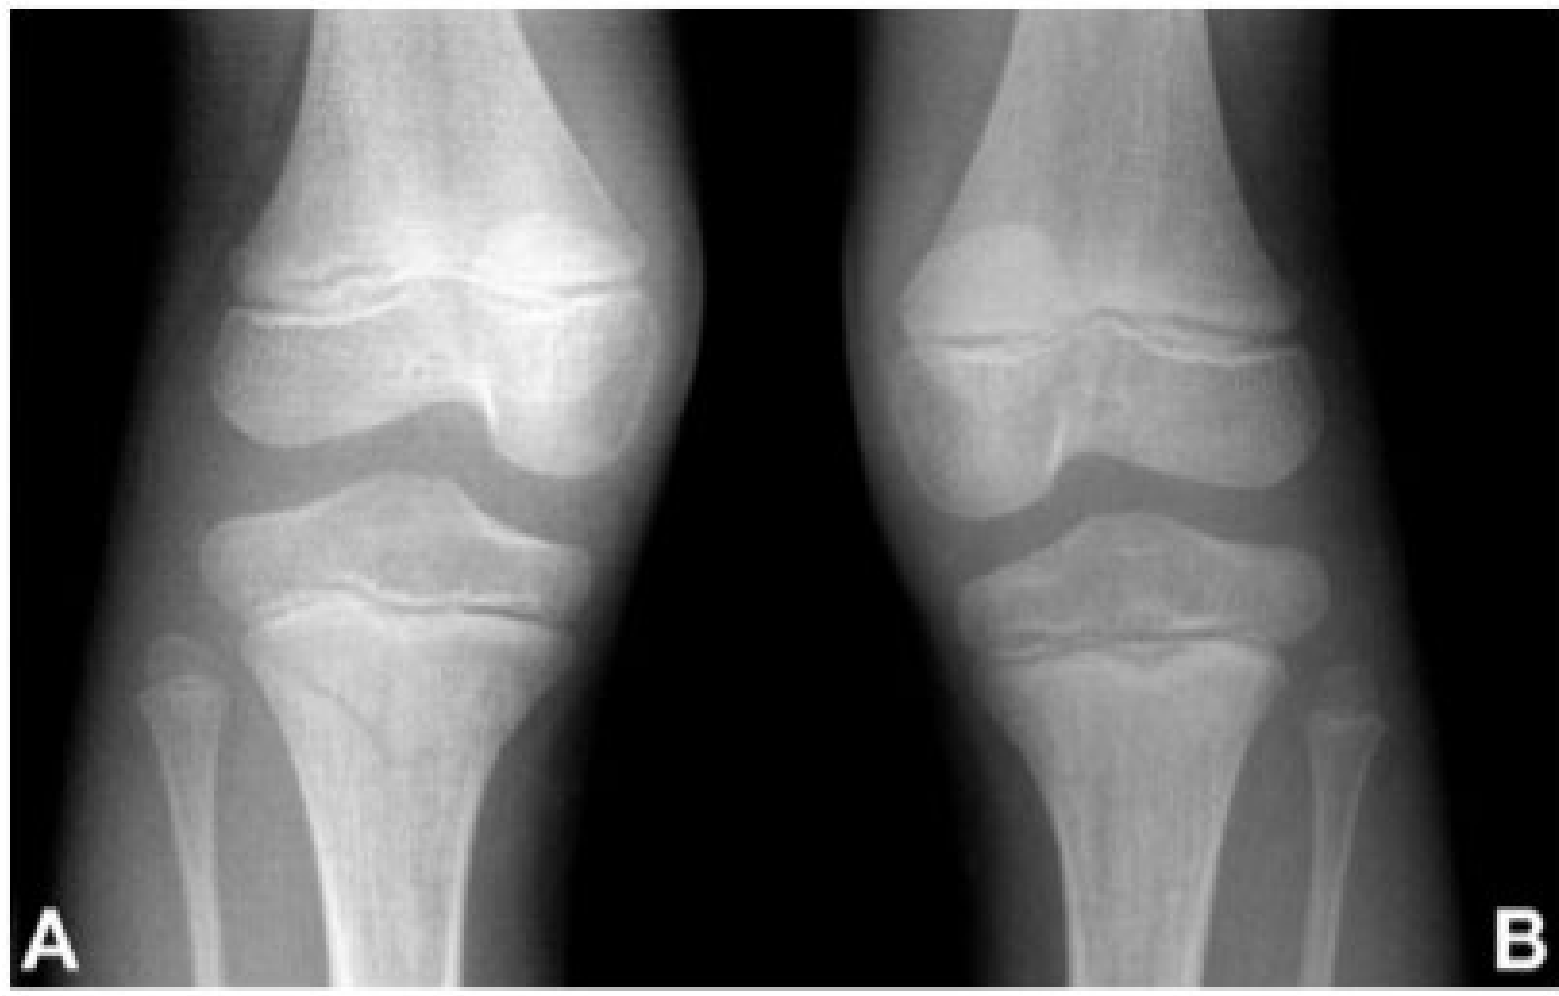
Baseline anteroposterior radiographs of the right (A) and the left (B) knees show bilateral minimally displaced fractures of the proximal tibial metaphysis (more evident on the right).
